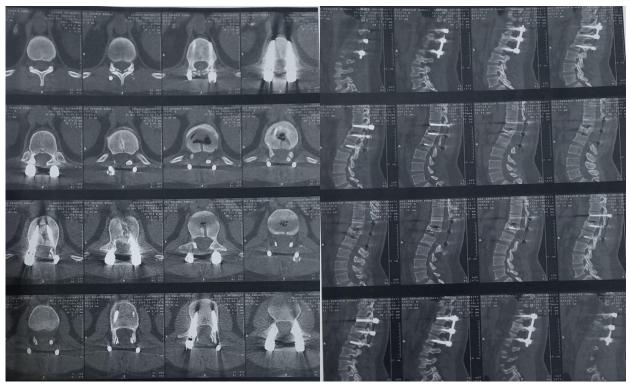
Post operative CT scan at 3 months ,Axial and Sagittal reveal good decompression to the spinal canal , the all transpedicular screws and both rods are hold in proper place.
